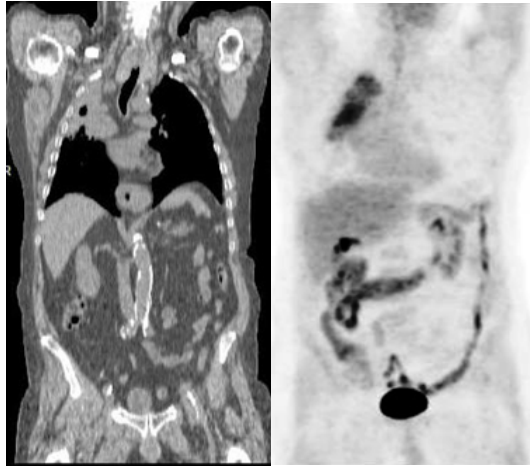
CT and PET coronal images; A 54-year-old man had completed radiotherapy of the right lung for recurrent NSCLC. The images show typical dome-shape consolidative changes with increased FDG accumulation in radiation pneumonitis. (Images courtesy of Peter Mac Callum Centre)
